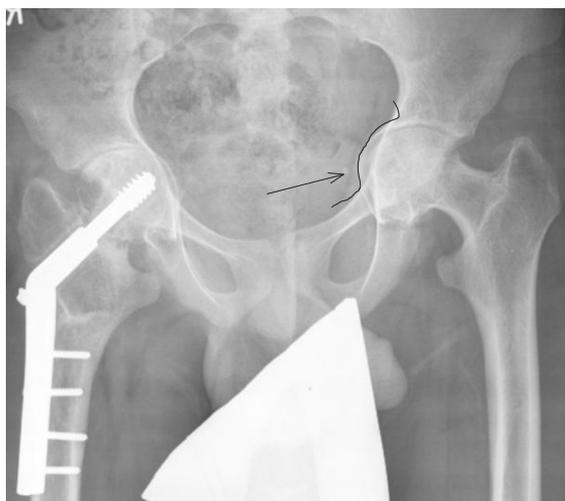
Pelvic X-ray of a young patient treated for a subcapital fracture of the femoral neck of his right hip. Although not defined as a Marfan patient he does have many of the musculoskeletal characteristics of Marfan syndrome. Note the distinct protrusio acetabuli on both sides, more prominent on the left (arrow pointing to the line marking the acetabular border protruding into both columns)
